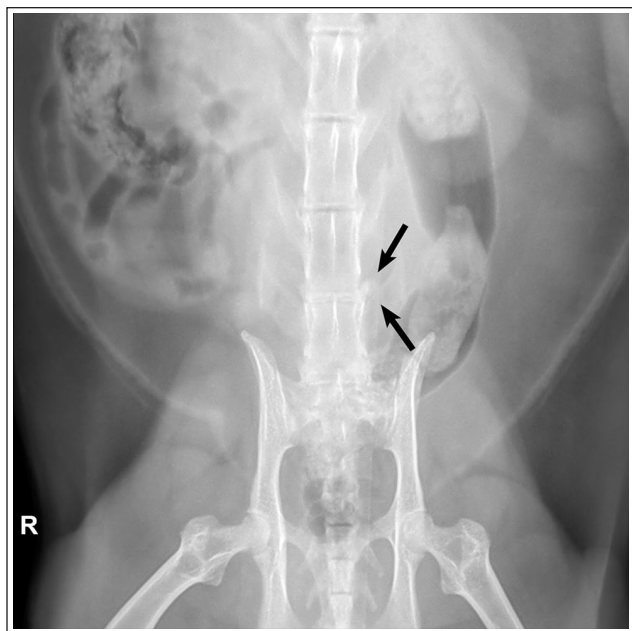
Ventrodorsal radiograph of the pelvis and lumbosacral spine revealing a narrowed L6–7 intervertebral disc space and a mineralized disc (black arrows) that has extruded laterally into the left intervertebral foramen
